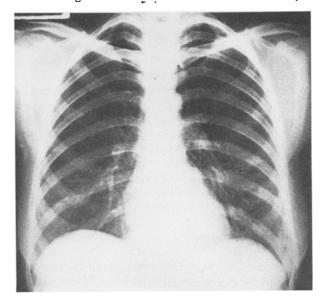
Case 2. Chest x-ray appearance of the same patient 10 days following severe pulmonary aspiration. At the height of the illness a membrane oxygenator was required in order to maintain an adequate  $PaO_2$
